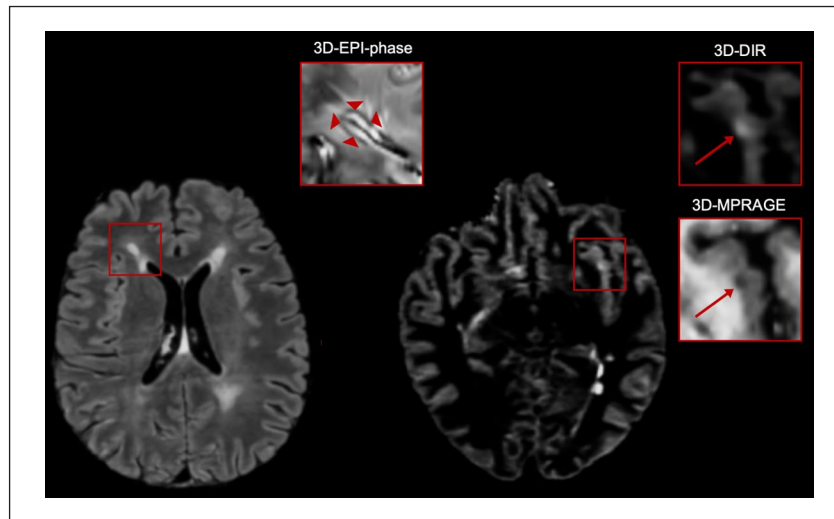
Representative 3T brain MRI of an adult participant with an EDSS score of 2, showing 11 paramagnetic rim lesions on 3D-EPI phase imaging and 3 cortical lesions on 3D-DIR and 3D-MPRAGE. This participant reported a daily intake of trans-fatty acids of 1.25 g (above the 75th percentile).
